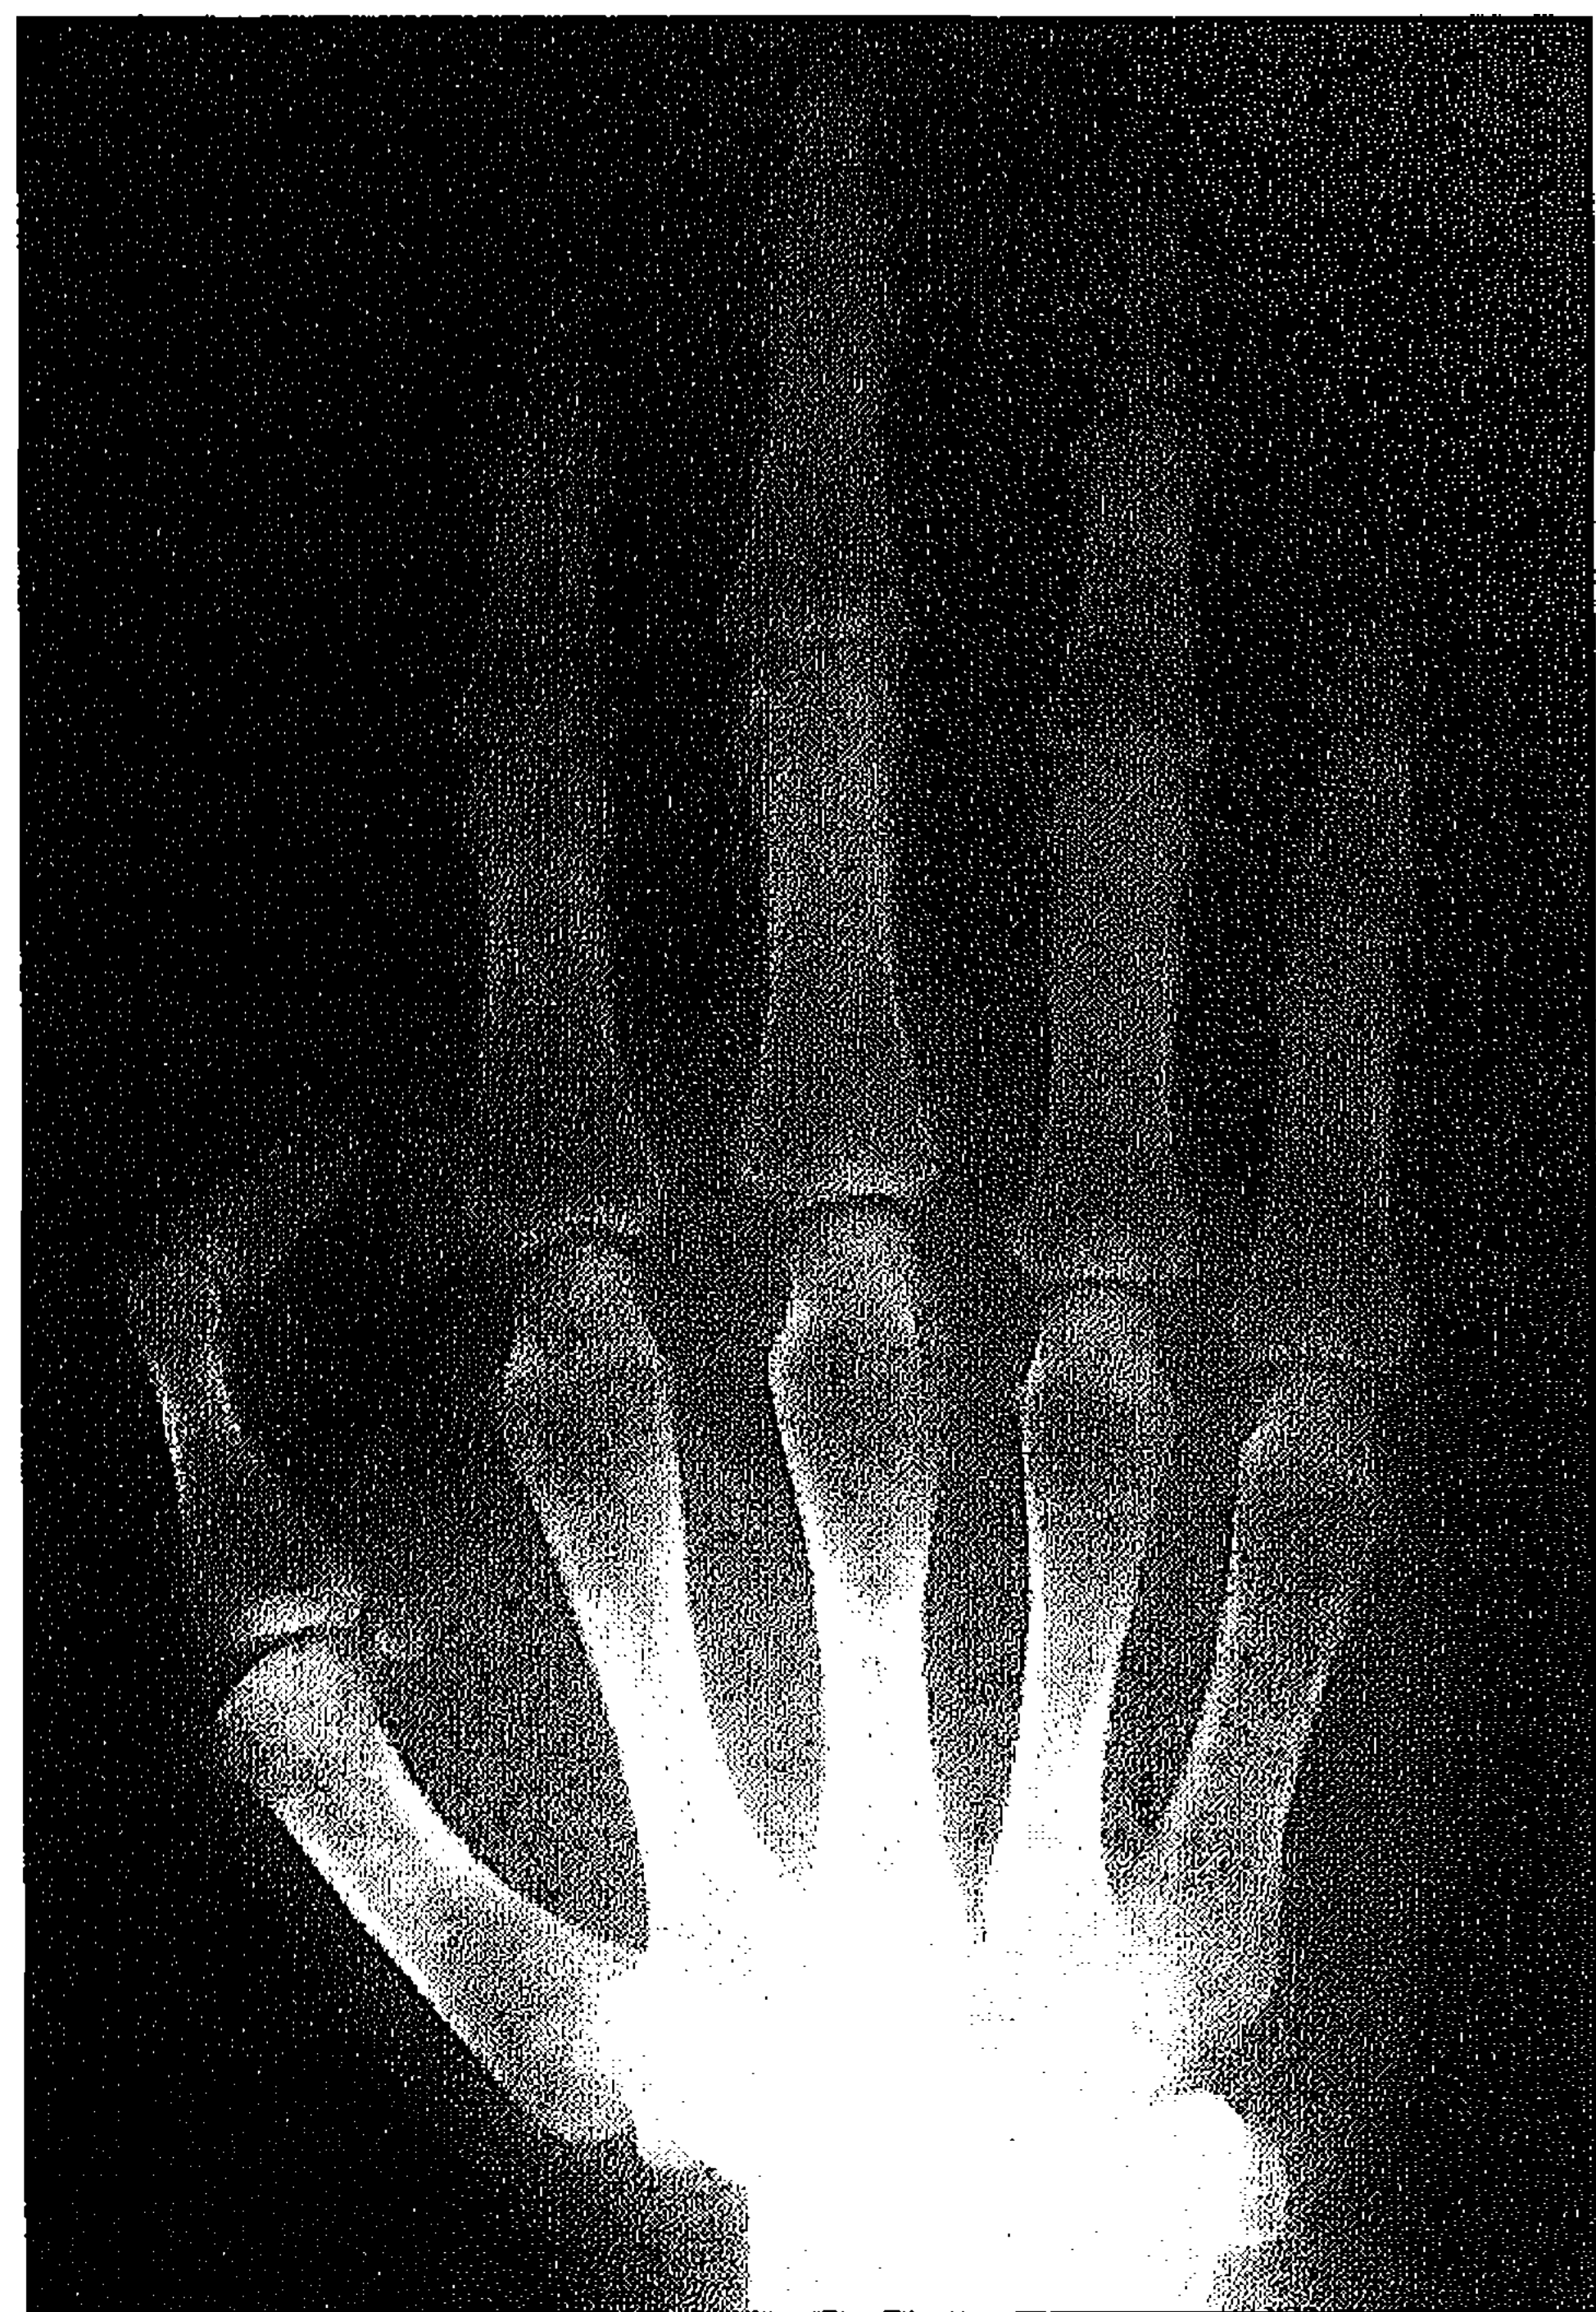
X-ray of the right hand, note subluxation of the thumb and the short, broad distal phalanges and the hypoplastic distal phalanges of the second and fifth fingers.
